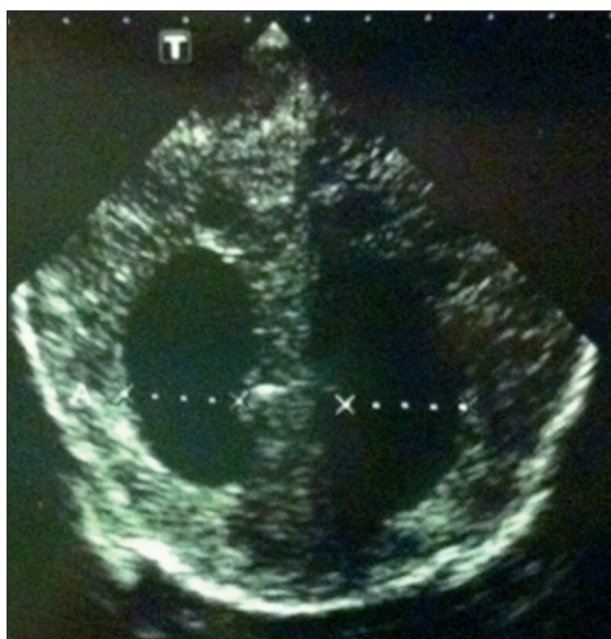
Intraventricular, parenchyma and subarachnoid haemorrhage in the transfontanelar ultrasound of case 4.
